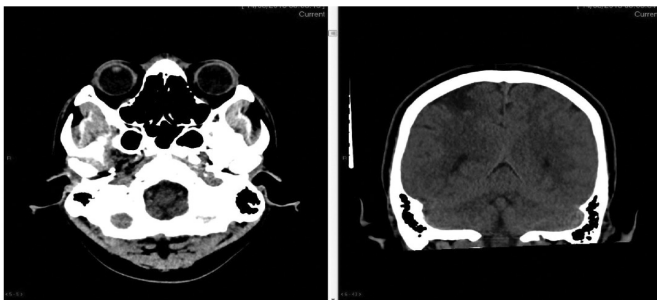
Brain computed tomography demonstrating global cerebral edema with diffuse sulcal and basal cisternal effacement and tonsils are seen at the level of foramen magnum
